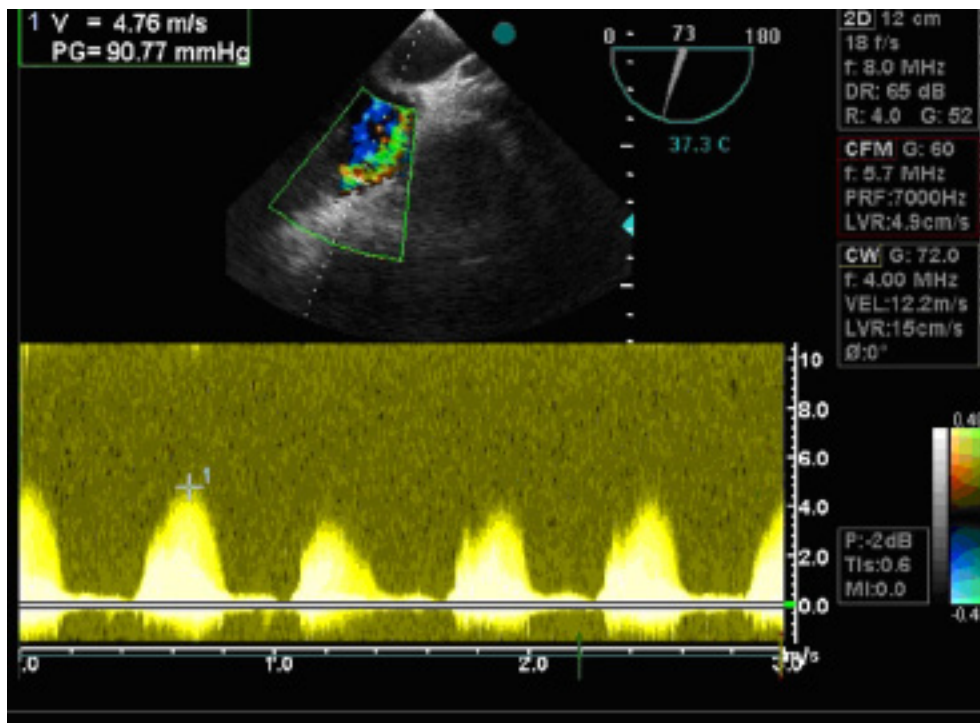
Color Doppler echocardiography shows severe pulmonary stenosis with maximum pressure gradient of 90 mmhg.
